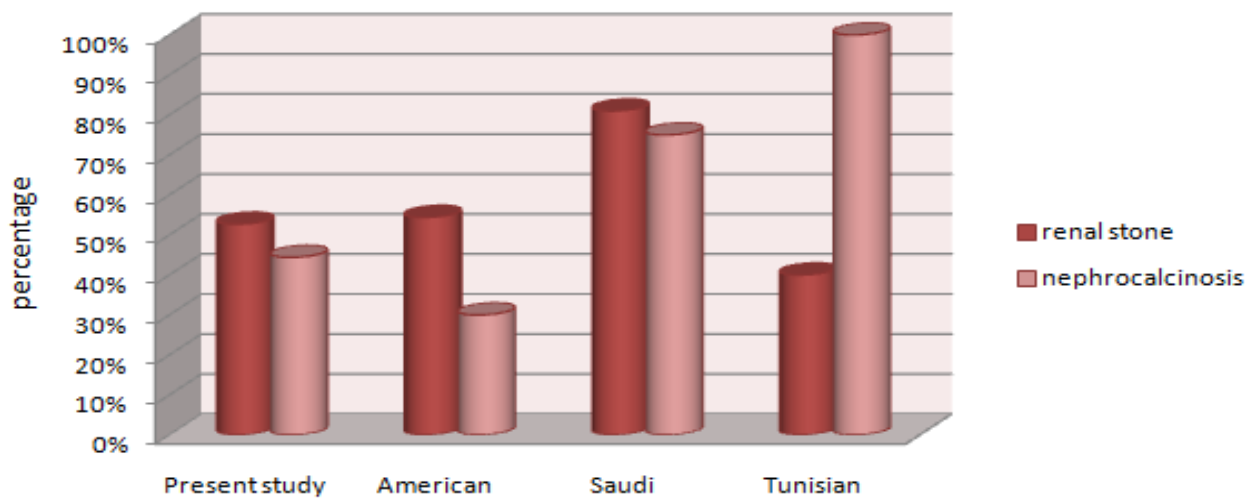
The sonography pattern in different studies.
